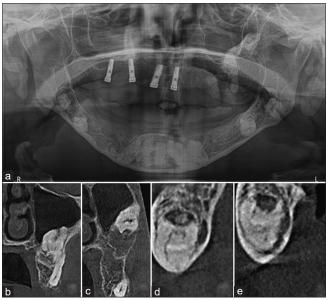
(a) Panoramic Radiograph showing the overall condition; (b-e) CBCT cross-sectional slices, note the presence of impacted teeth compared with that of the altered pericoronal follicle and small calcifications surrounding the crown of these teeth. CBCT: Cone-beam computed tomography
